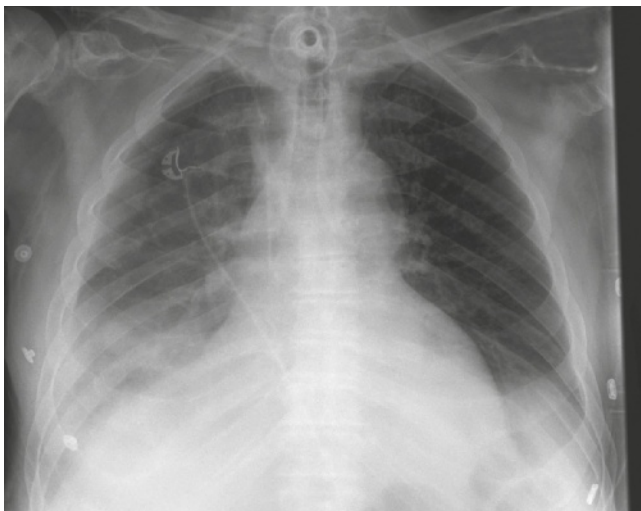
Radiography of the thorax (anteroposterior beam): Pneumonic infiltrates can be seen in the area of the right lower lobe of the lung.
